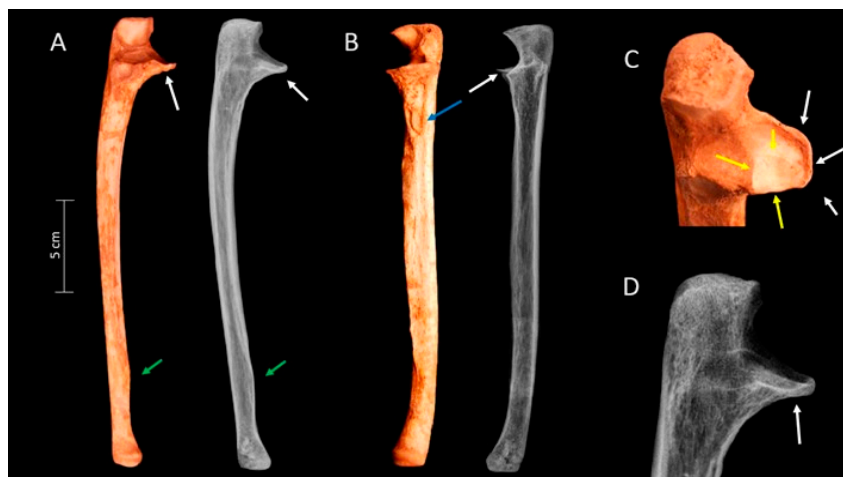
Lateral view of the right ulna with the associated radiograph (A). Anterior view of the right ulna with the associated radiograph (B). Magnification of the proximal epiphysis of the right ulna (C) and its radiographic image (D). White arrows show remodeling of the fracture at the coronoid process of the right ulna. Green arrows show prominent pronator quadratus muscle insertion. Blue arrows indicate a prominent insertion of the brachialis muscle. Yellow arrows indicate an eburnation at the coronoid facet.
